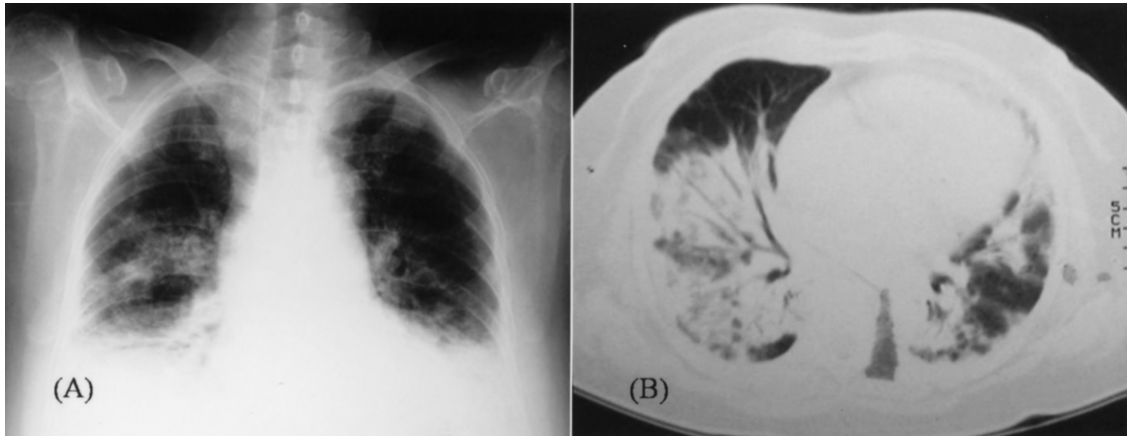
Cryptogenic organizing pneumonitis with multiple patchy opacities. (A) Chest X-ray showing bilateral patchy infiltrates. (B) CT scan showing consolidation with air bronchogram.
